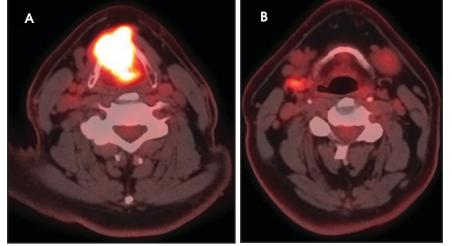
Axial PET/CT images demonstrating a 3.5-cm laryngeal neoplasm centered in the right vocal cord but crossing the midline (A), and a right level IIa mildly FDG avid lymph node, suspicious for metastasis (B).
